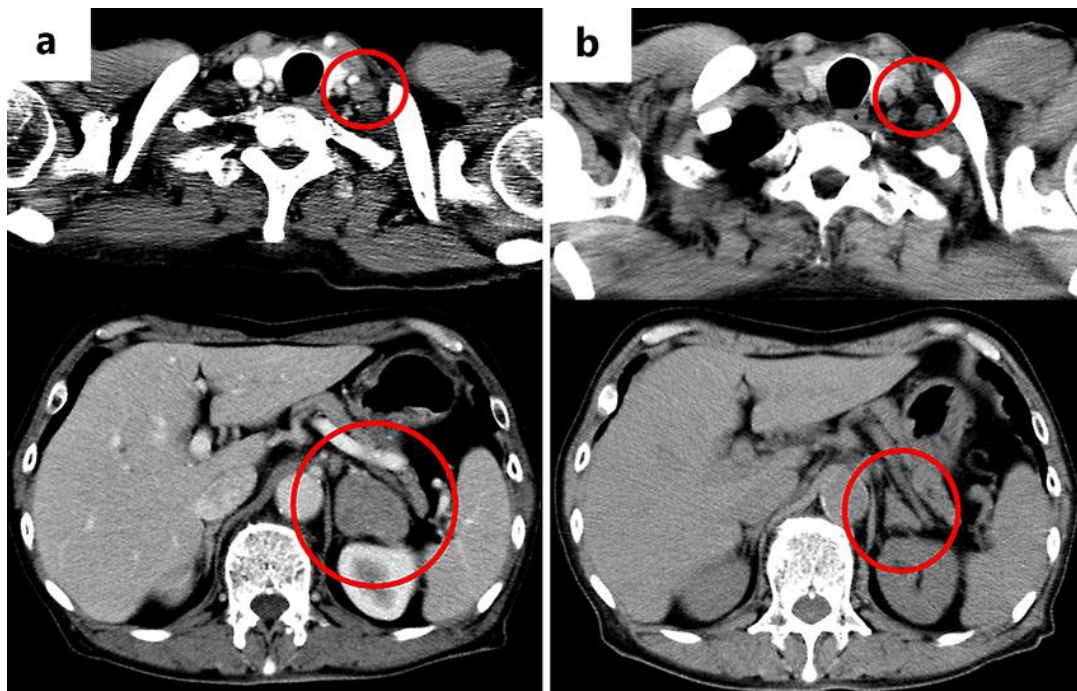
The course of the target lesion. a Recurrent lesion before nivolumab administration. CT scan showing an enlarged left supraclavicular lymph node and left adrenal gland. b CT scan after 4 cycles of nivolumab treatment, revealing that the swelling of the left supraclavicular lymph node and left adrenal gland has reduced.
